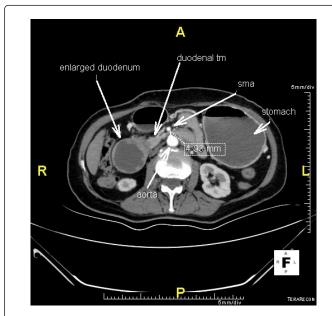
Duodenum tumor in axial plan in computed tomography.
